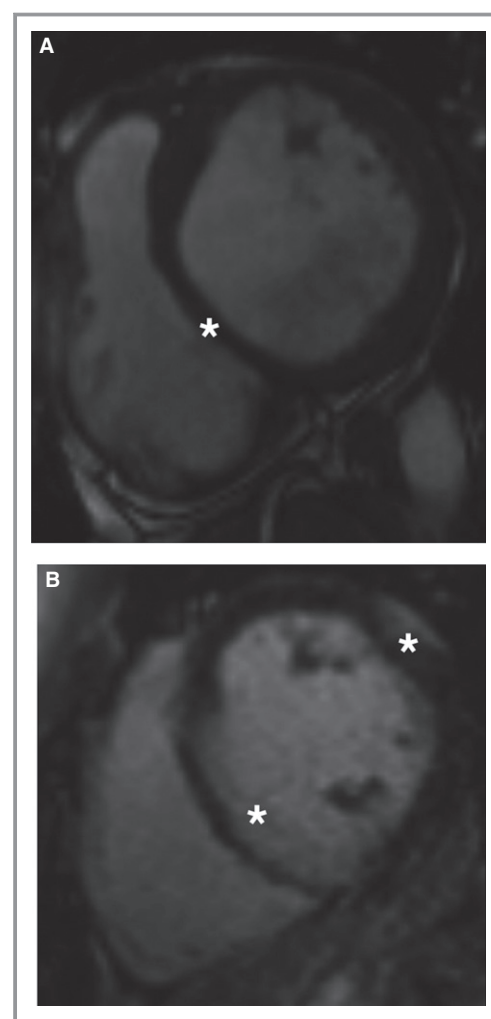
Examples of basal short-axis cardiac magnetic resonance imaging showing pathological thinning of the basal septum (A, asterisk) and late gadolinium enhancement in the interventricular septum and in the lateral left ventricular wall (B, white asterisks).
